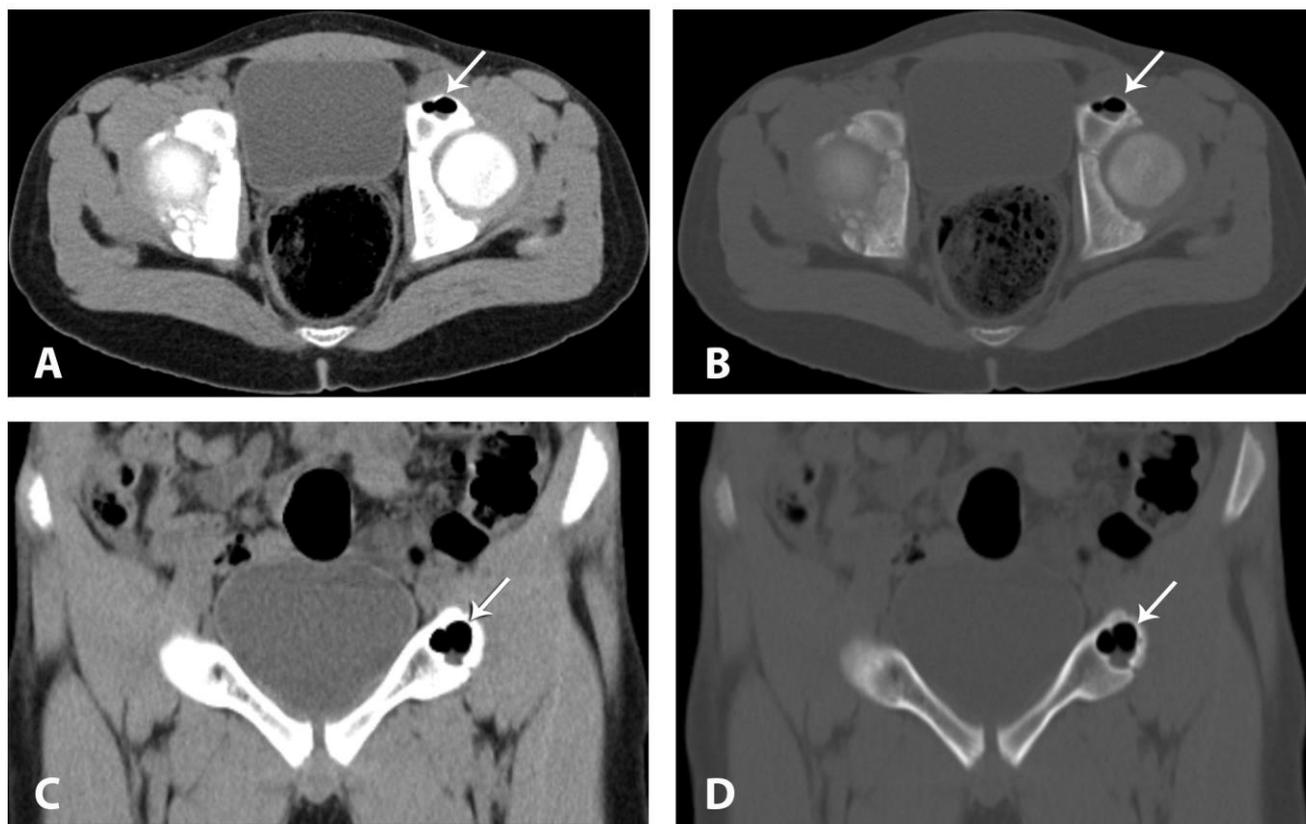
Fourteen year-old boy with incidental left acetabular intraosseous pneumatocyst. Axial CT scan (a) soft tissue window (b) bone window. Coronal CT scan (c) soft tissue window (d) bone window. It shows a gas density - fluid level well circumscribed lobulated lesion with thin sclerotic margin (arrows) involving pubic bone portion of the left acetabulum. Note the normal appearance of adjacent bone, hip joint and surrounding soft tissue. [Technique CT, 106mAs, 120 KVP, 3mm SL, without contrast].
